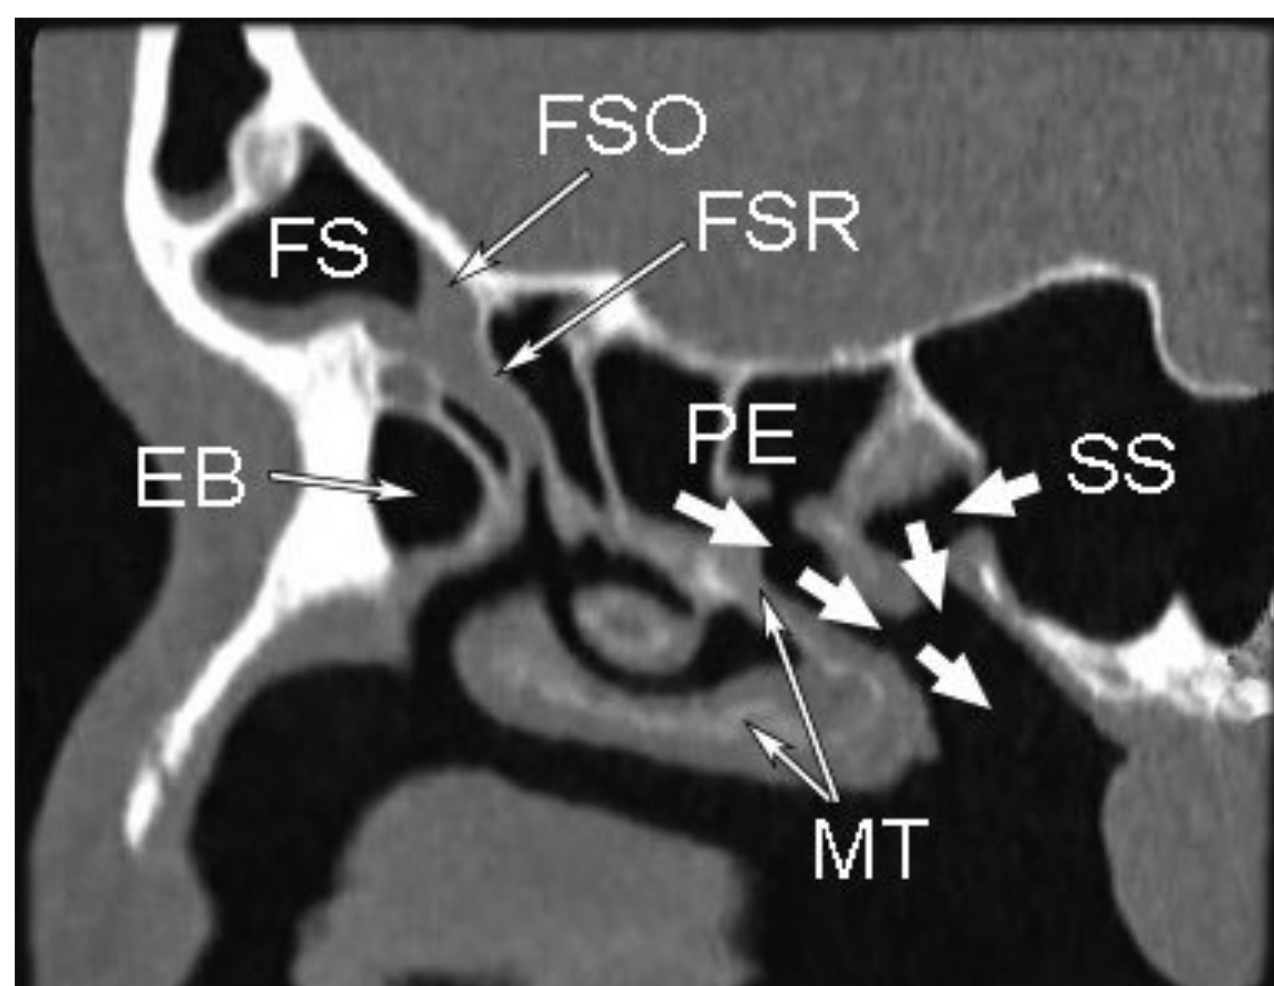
Parasagittal reformation of CT scan through the sinuses demonstrates the frontal sinus (FS), the frontal sinus ostium (FSO), and the frontal sinus recess (FSR). The frontal sinus recess is conical shaped and extends inferiorly into the medial meatus. Also identified is the ethmoid bulla (EB), posterior ethmoid air cells (PE), and the sphenoid sinus (SS). The middle turbinate (MT) is labeled.
